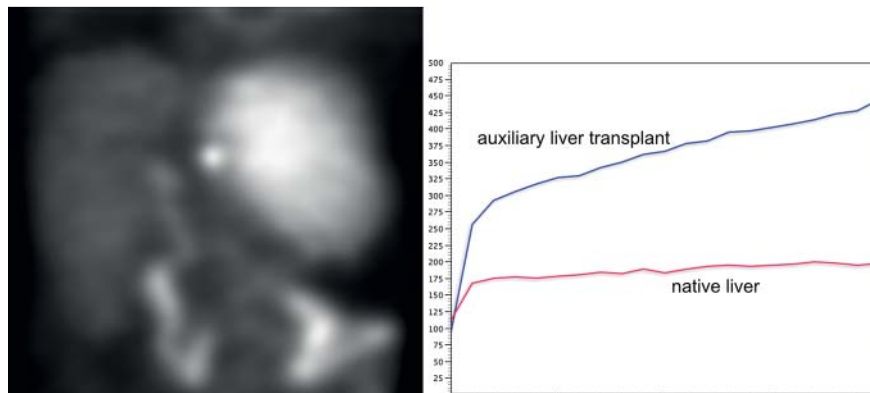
^{99m}Tc -mebrofenin scintigraphy 1 week after auxiliary liver transplantation. The left figure shows planar image after 45 minutes with 45° RAO detector rotation. The right figure shows the two time activity curves of the first 10 minutes after tracer application.
